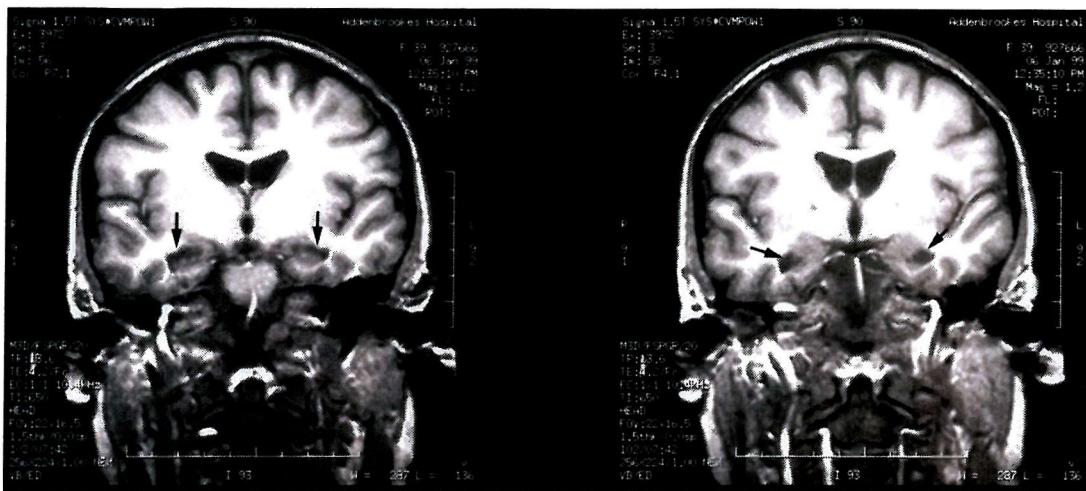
Coronal MRI images of BW's brain showing hippocampal atrophy (arrowed).
